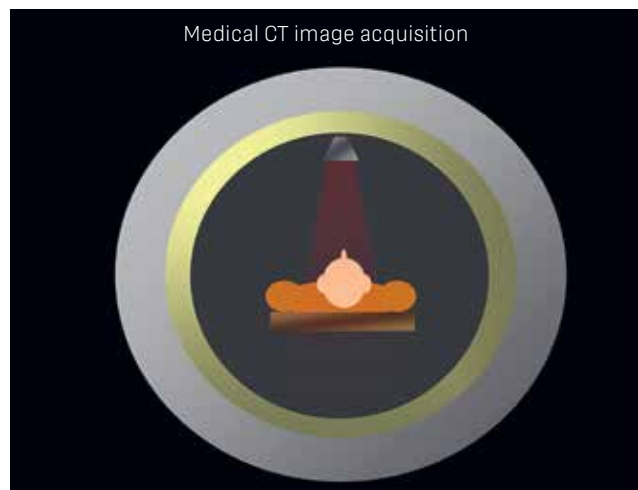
Medical CT image acquisition involves a thin fan-shaped rotating beam, a ringlike array of detectors (*yellow ring*), and a supine patient. The x-ray source scans the area of interest with multiple rotations, collecting x-ray attenuation data.
